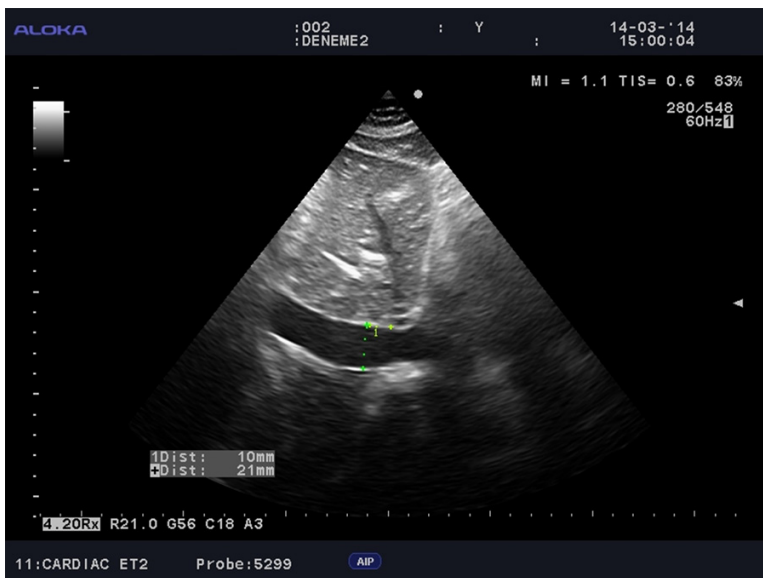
Ultrasonographic determination of inferior vena cava diameter.
